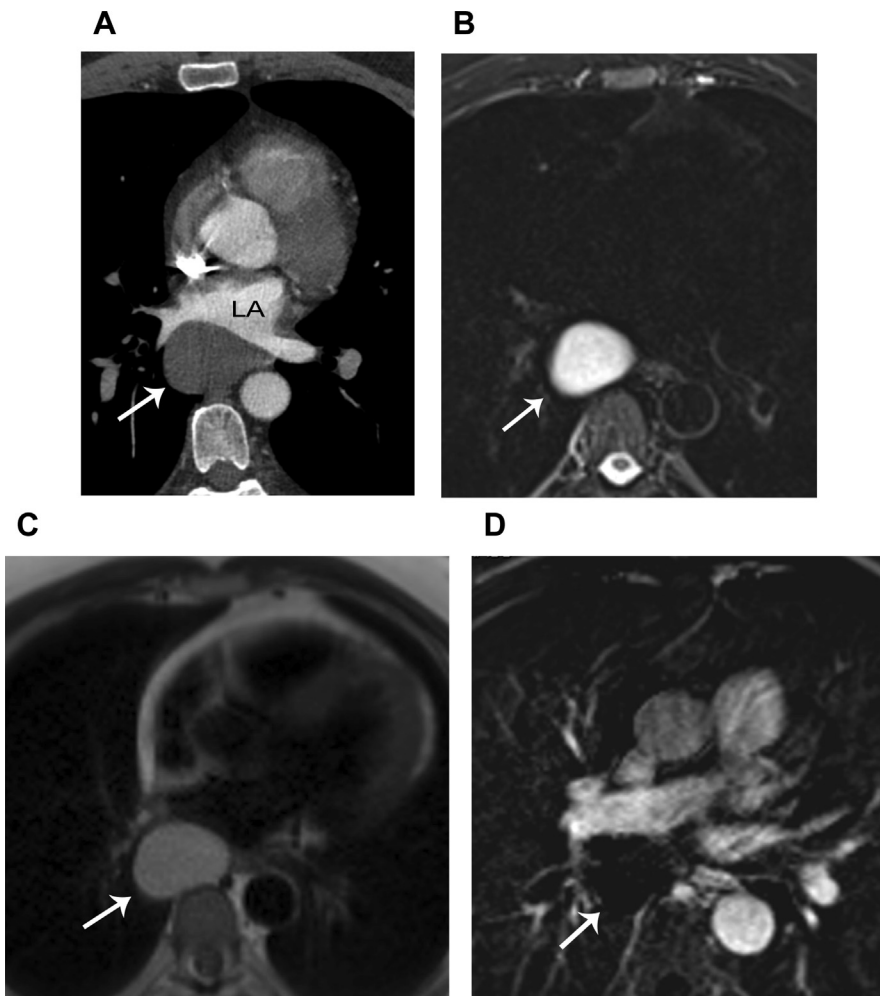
A bronchogenic cyst in a 50-year-old woman with persistent cough. (A) A contrast-enhanced axial CT scan of the chest at the level of the left atrium (LA) demonstrates a homogeneous low attenuation (38 Hounsfield units) mass (*arrow*) in the visceral mediastinum compressing the left atrium. On CT scan, cysts with hemorrhage or proteinaceous material may demonstrate density similar to soft tissue and can be misinterpreted as solid lesions. (B) An axial T2-weighted MR image demonstrates homogeneous high signal intensity in the lesion (*arrow*), consistent with a cyst. (C) An axial T1-weighted MR image demonstrates homogeneous high signal intensity relative to muscle (*arrow*). The high signal intensity on both T1- and T2-weighted images confirms the proteinaceous cyst content. (D) A subtracted fat-suppressed axial T1-weighted MR image after the administration of intravenous gadolinium contrast demonstrates no enhancement of either the lesion or its wall (*arrow*) and no nodules. MR imaging is the optimal imaging modality for distinguishing cystic from solid lesions, identifying cystic and/or necrotic lesion components, and characterizing cystic lesions as to the presence of septations and mural nodularity.
